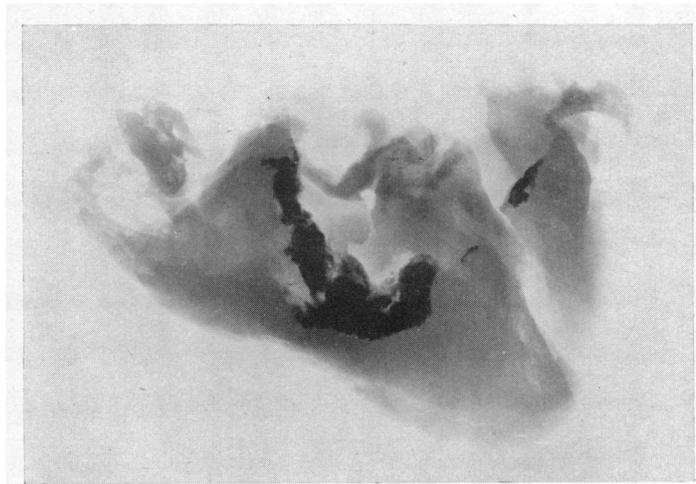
Radiograph of isolated heart, showing extensive granular deposits of calcium beneath the endocardium of the right ventricle, which has undergone advanced obliteration (Case 1).
